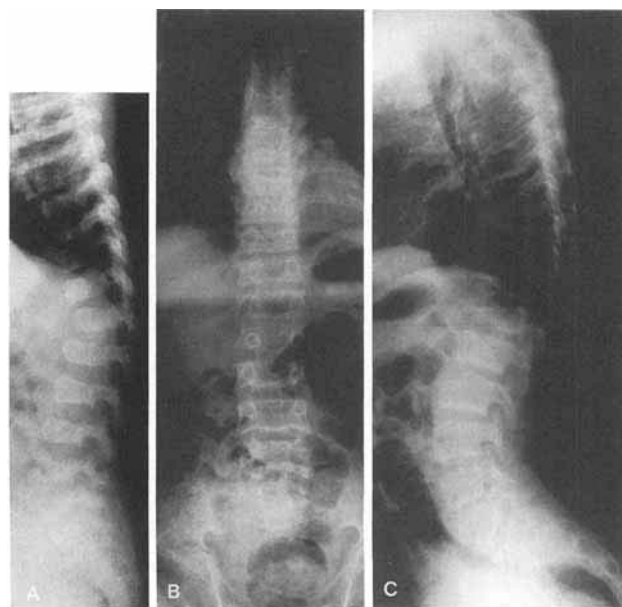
Spine of P1. In radiographs at age 1½ years (A), 5 years (B), and (C) the mild platyspondyly associates, at infancy, with rounded corners; and in adolescence, sclerotic endplates of the vertebral bodies. L1 is hypoplastic and repositioned, later wedge-shaped. There is a normal caudal increase in the interpedicular distance and L5 spina bifida occulta. In adolescence, the patient has a mild thoracolumbar kyphosis and marked increase in lumbosacral angle.
